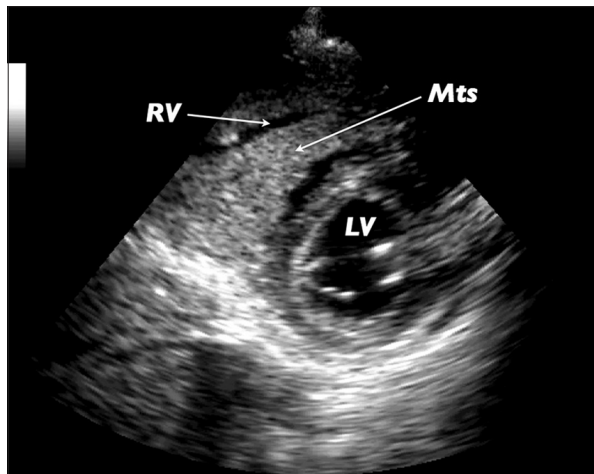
Parasternal short axis view. Metastasis occupying the right ventricle (RV = Right Ventricle; Mts = Metastasis)
